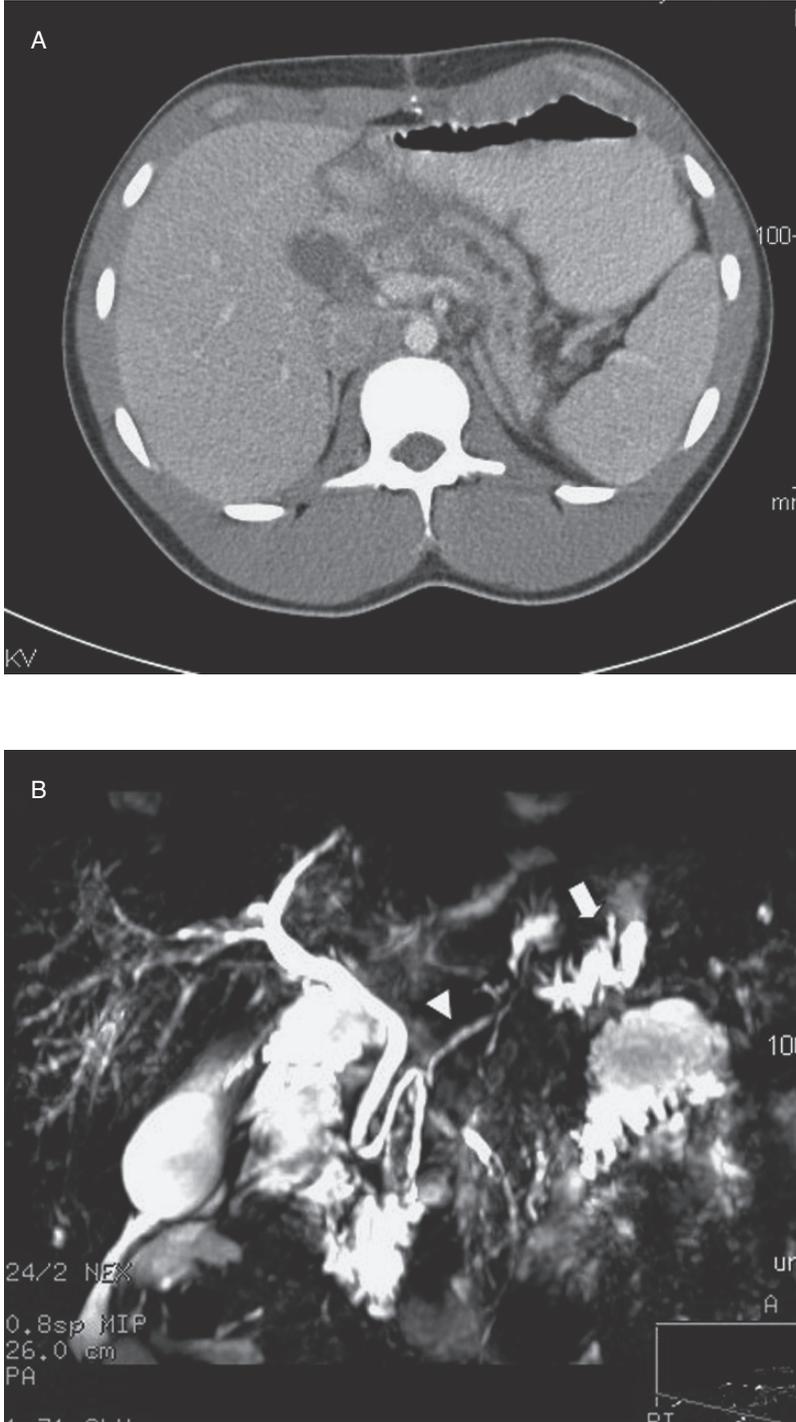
(A) CT of a patient with recurrent pancreatitis after blunt abdominal trauma. (B) MRCP shows a normal proximal pancreatic duct (triangle), a high-grade mid-ductal stricture, and a dilated, tortuous distal duct (arrow).
